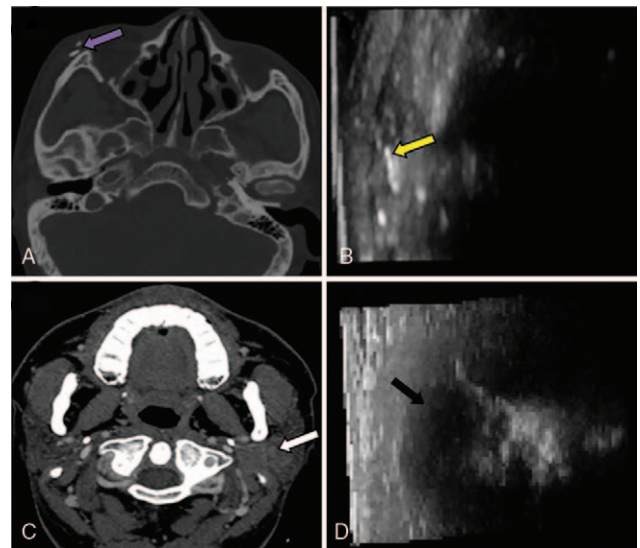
(A) The original CT scan image of a foreign body (indicated by purple arrow) in the face. (B) The location of the foreign body (yellow arrow) in the ultrasound image. (C) An enhanced CT of a left parotid mass (white arrow). (D) An ultrasound image of the parotid mass (black arrow). CT, computed tomography.
